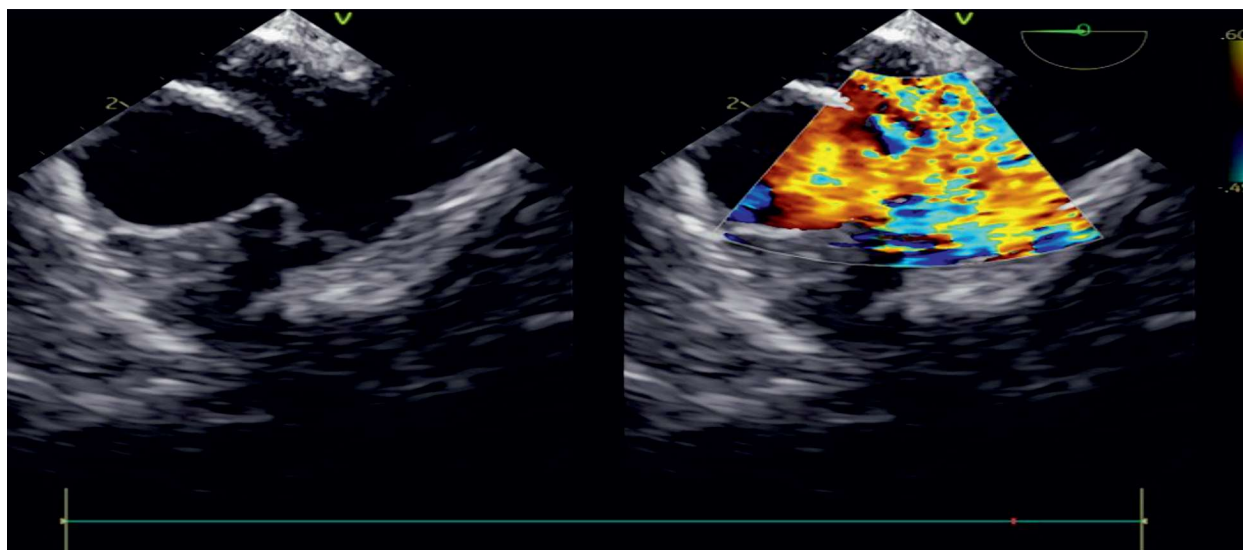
Mid-esophageal ascending aorta short axis view showing the communication between the aorta and the main pulmonary artery with color doppler showing the flow across it
